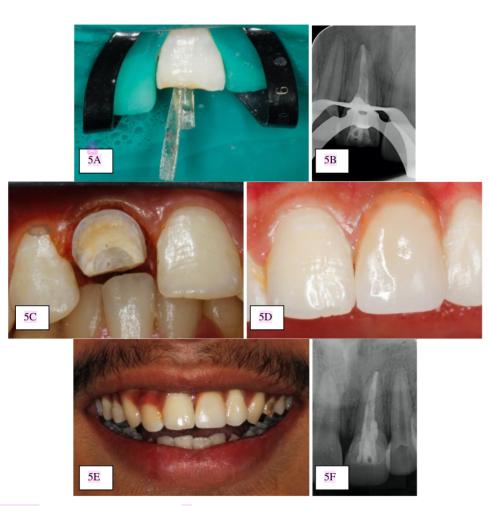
Final restoration sequences of teeth #21 in case 1. A. Cementation of fiber post using resin cement. B. Radiograph confirmation of post placement. C. Crown preparation, followed by imprint and record bite registration. D. Cementation of the crown on the next visit. E. One month recall showed the restoration was still in good condition. F. Radiograph confirmation one month after the treatment showed healing of the periapical tissue.
